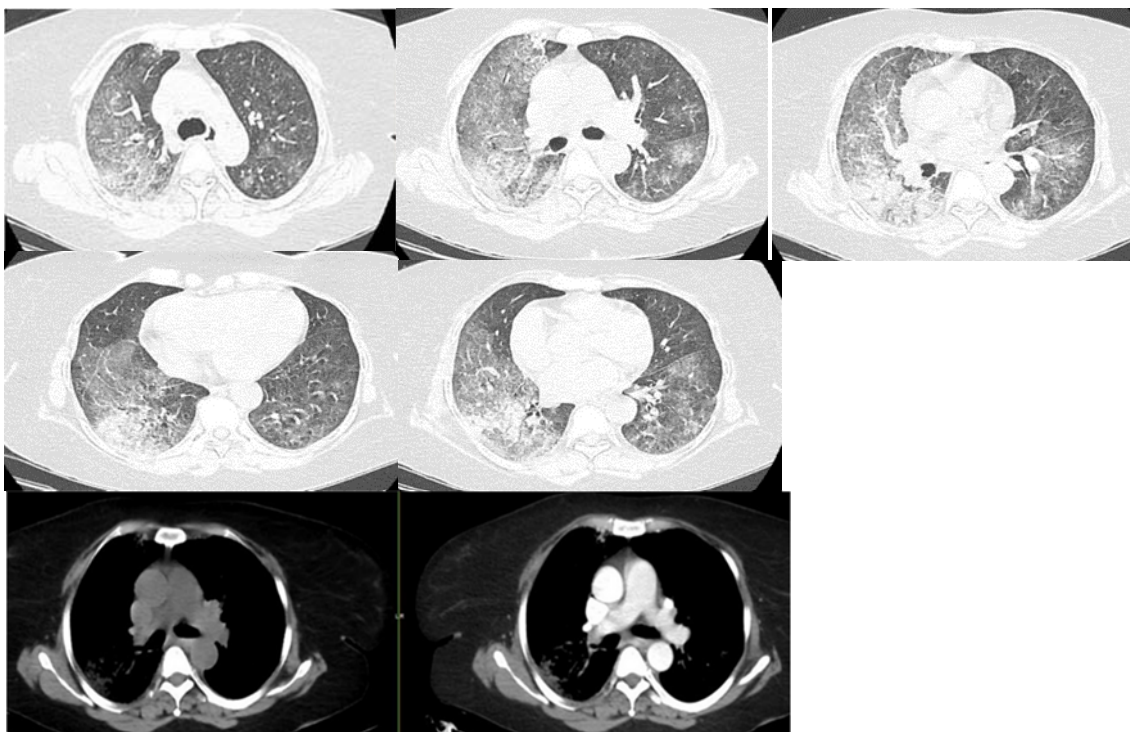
Axial lung and mediastinal windows of the high-resolution chest CT scan (was done at admission) showing bilateral (more diffused on the right lung and patchy on the left lung) alveolar filling and ground-glass opacification, mainly in the right lung with interval worsening from initial CT, consistent with pulmonary hemorrhage.
